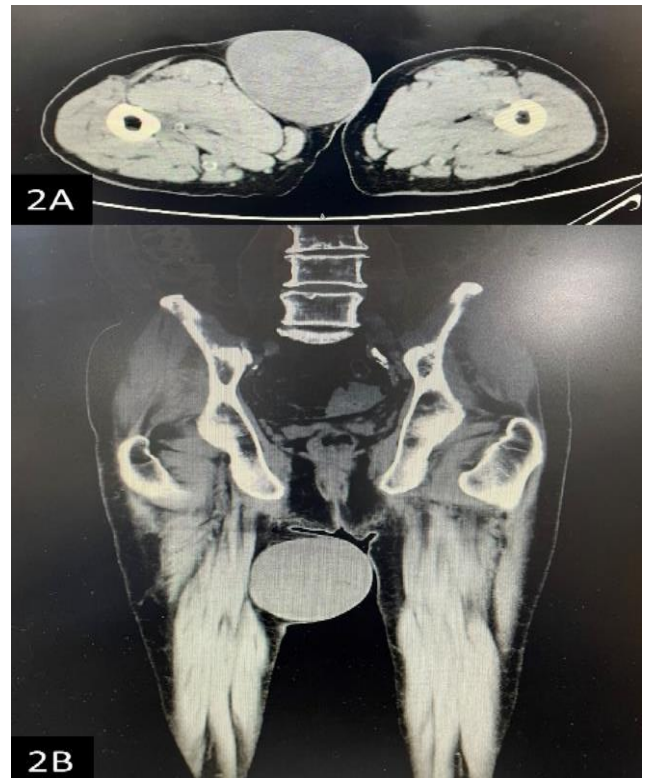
(A and B): Contrast-enhanced computed tomography images of the swelling, axial section; coronal section; CECT of the abdomen and pelvis showing a thin-walled, well-encapsulated, oval cystic mass in the right upper thigh region measuring 10.8×8.8×8.1 cm.
